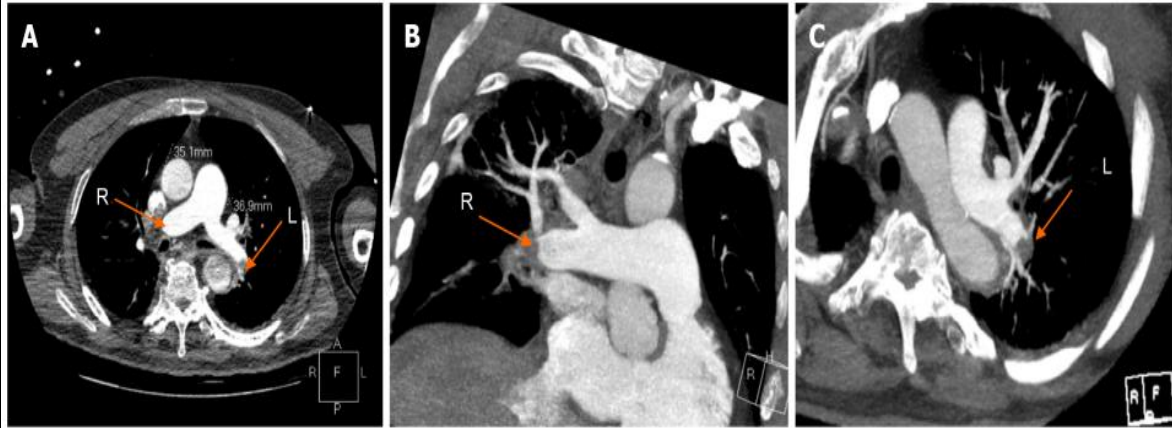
Contrast-enhanced computed CT findings. Orange arrows indicate thrombosis in both pulmonary arteries (A), extension to the distal right interlobar artery (B), and extension to the left interlobar pulmonary artery (C).
